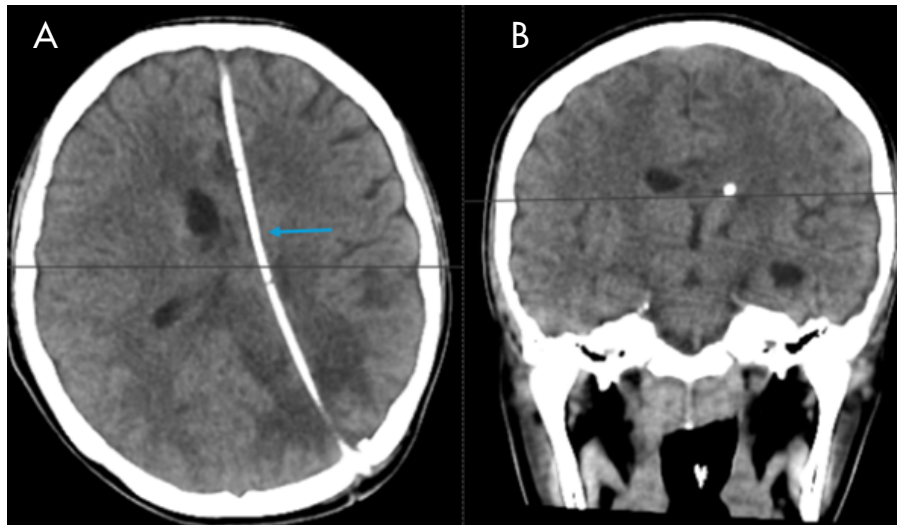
Non-contrast CT scan of the skull (a: axial view; b: coronal view) showing an external ventricular drain catheter lodged in the interhemispheric fissure (arrow), with no evidence of hydrocephalus.
